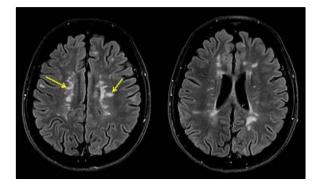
MRI T2-FLAIR periventricular region.
